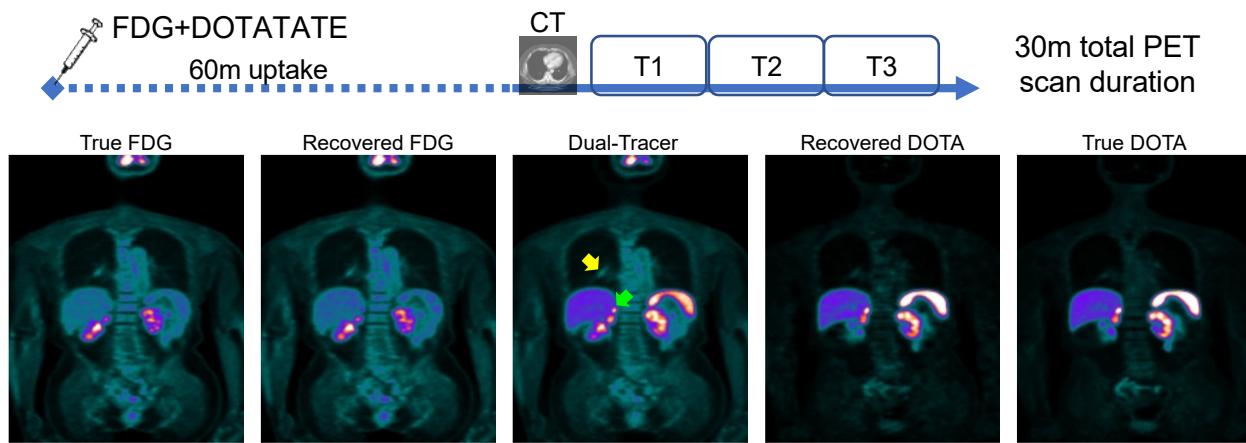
Simultaneous FDG+DOTATATE scan protocol (top) and example FDG and DOTATATE images for 30m simultaneous scan (bottom). The recovered FDG and DOTATATE images closely match the true images, with areas of focal uptake (arrows) effectively (but not perfectly) recovered for each tracer.
